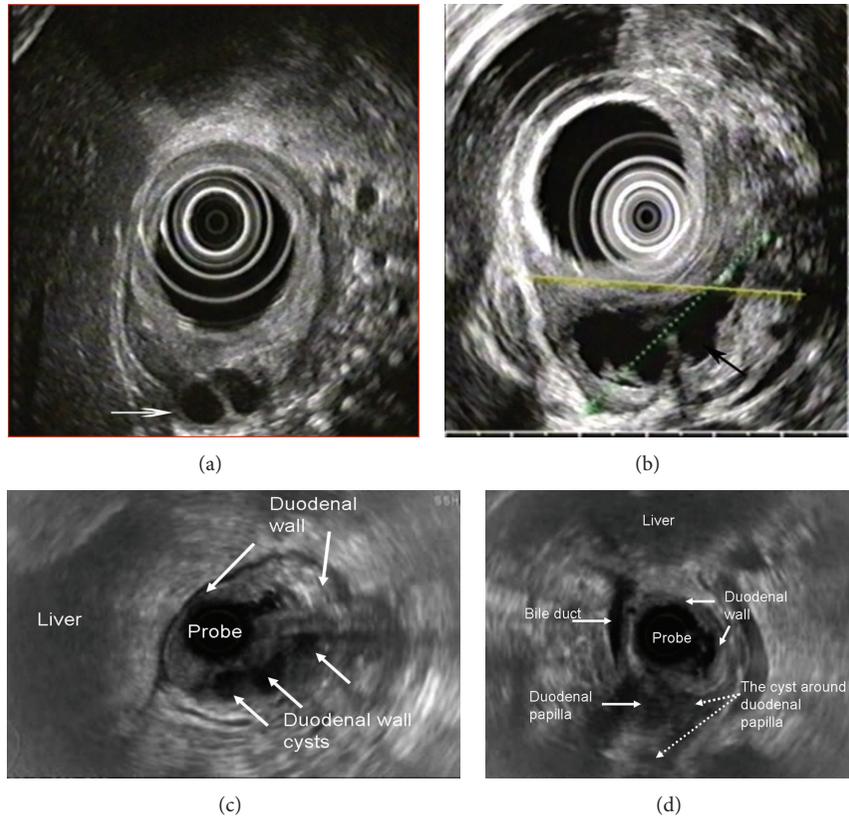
Endosonography. Duodenal dystrophy with moderate chronic orthotopic pancreatitis. (a) Patient 32 y.o. Ovoid septated cystic structure in the submucosa and muscularis of the diffusely thickened duodenal wall (arrow); (b) patient 43 y.o. Large septated multiloculated cyst in the submucosa and muscularis of the diffusely thickened duodenal wall (arrow). (c) Male 57 y.o. Isolated form of the duodenal dystrophy with unchanged orthotopic pancreas. Septated cystic structure (three arrows) in the submucosa and muscularis of the diffusely thickened duodenal wall (two arrows); (d) male, 57 y.o. Isolated form of the duodenal dystrophy with unchanged orthotopic pancreas. Septated cysts in the submucosa and muscularis of the diffusely thickened duodenal wall surround the major papilla.
